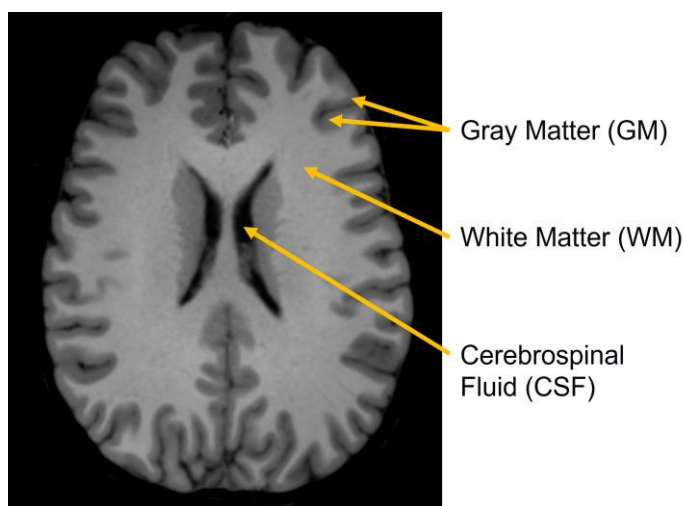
T₁-weighted MRI slice depicting clearly delineable gray matter (GM), white matter (WM), and cerebrospinal fluid (CSF) regions. In this contrast scheme, CSF appears black, WM is a bright gray, and GM is a darker gray. Note that the extra-cranial space, while also black, does not represent CSF. This image was acquired with appropriate Research and Ethics Board approval.
